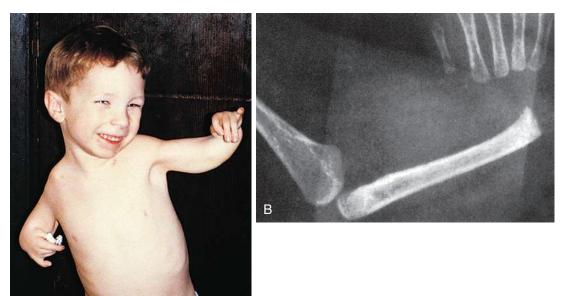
A, Child with thrombocytopenia–absent radius syndrome, also known as *TAR syndrome*. B, Radiograph of the same patient. Note the absence of the radius.
